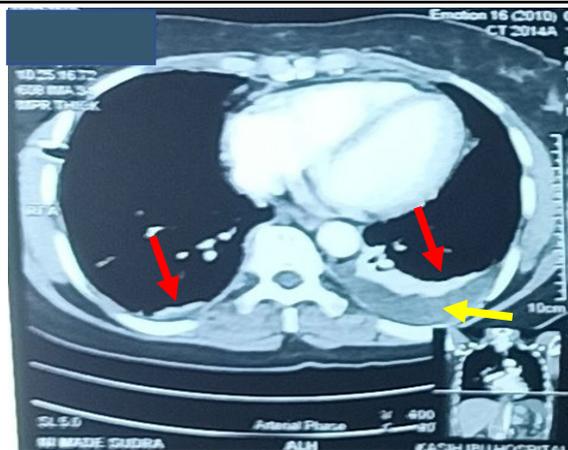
A CT scan of the thorax with contrast revealed right-left lung compaction with a fibrotic atelectasis component (red arrow) and pleural effusion (yellow arrow)
